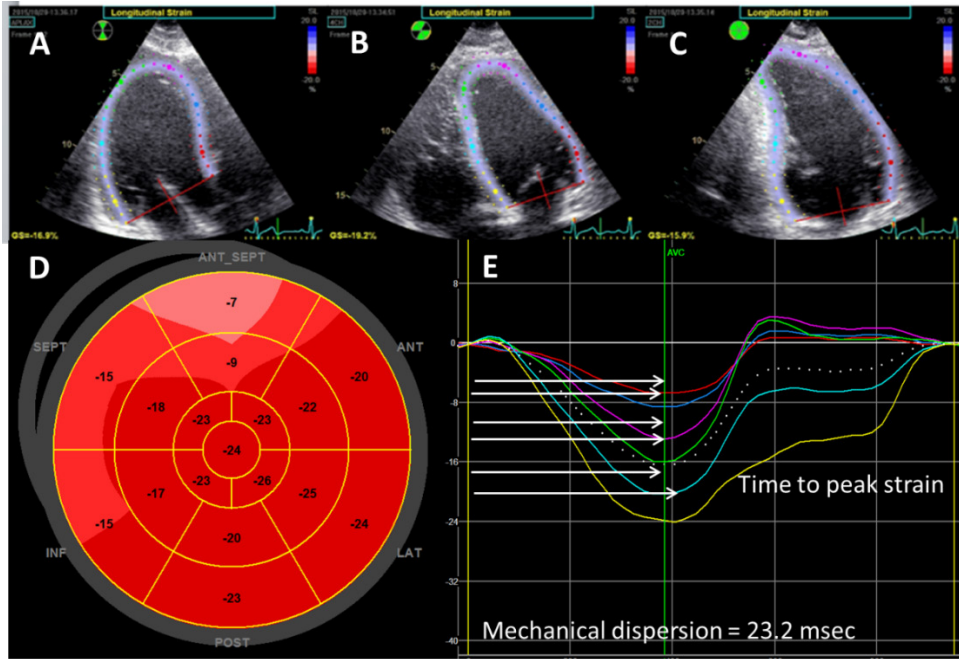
Left ventricular mechanical dispersion. Example of patient after anterior infarction. Panel A= speckle tracking analysis of apical long-axis ; Panel B= speckle tracking analysis of apical 4-chamber view; Panel C= speckle tracking analysis of apical 2-chamber view. Panel D= Bull's eye plots for global value of longitudinal strain which is calculated as the average of the 17 regional strain values, Panel E= mechanical dispersion (23.2 msec) with time to peak negative strain in all left ventricular segments.
